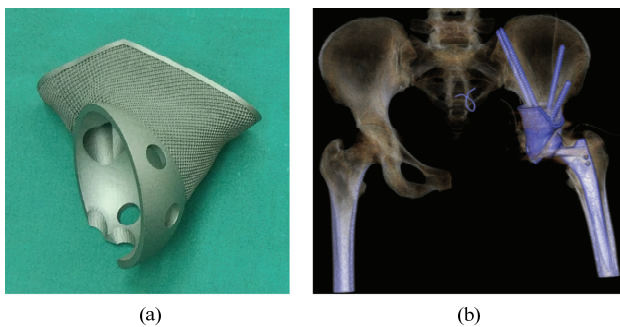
(a) 3D-printed prosthesis and (b) X-ray image of the reconstructed pelvis after clinical implantation (provided by Xijing Hospital).
